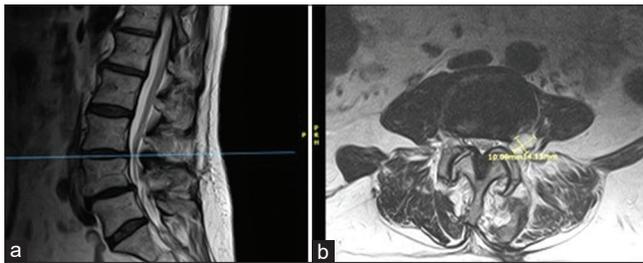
Postoperative magnetic resonance imaging without contrast after first surgery. (a) T2 parasagittal. Cystic-appearing lesion approximately 1.4 × 1.0 cm in the left L3–4 neural foramen visible on (b) T2 axial at L3–4.
